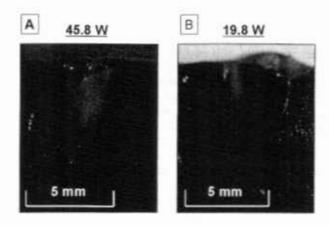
Representative high-intensity focused ultrasound-treated myocardial lesions using power of 45.8 W (A) and 19.8 W (B) with 1-second pulses.
